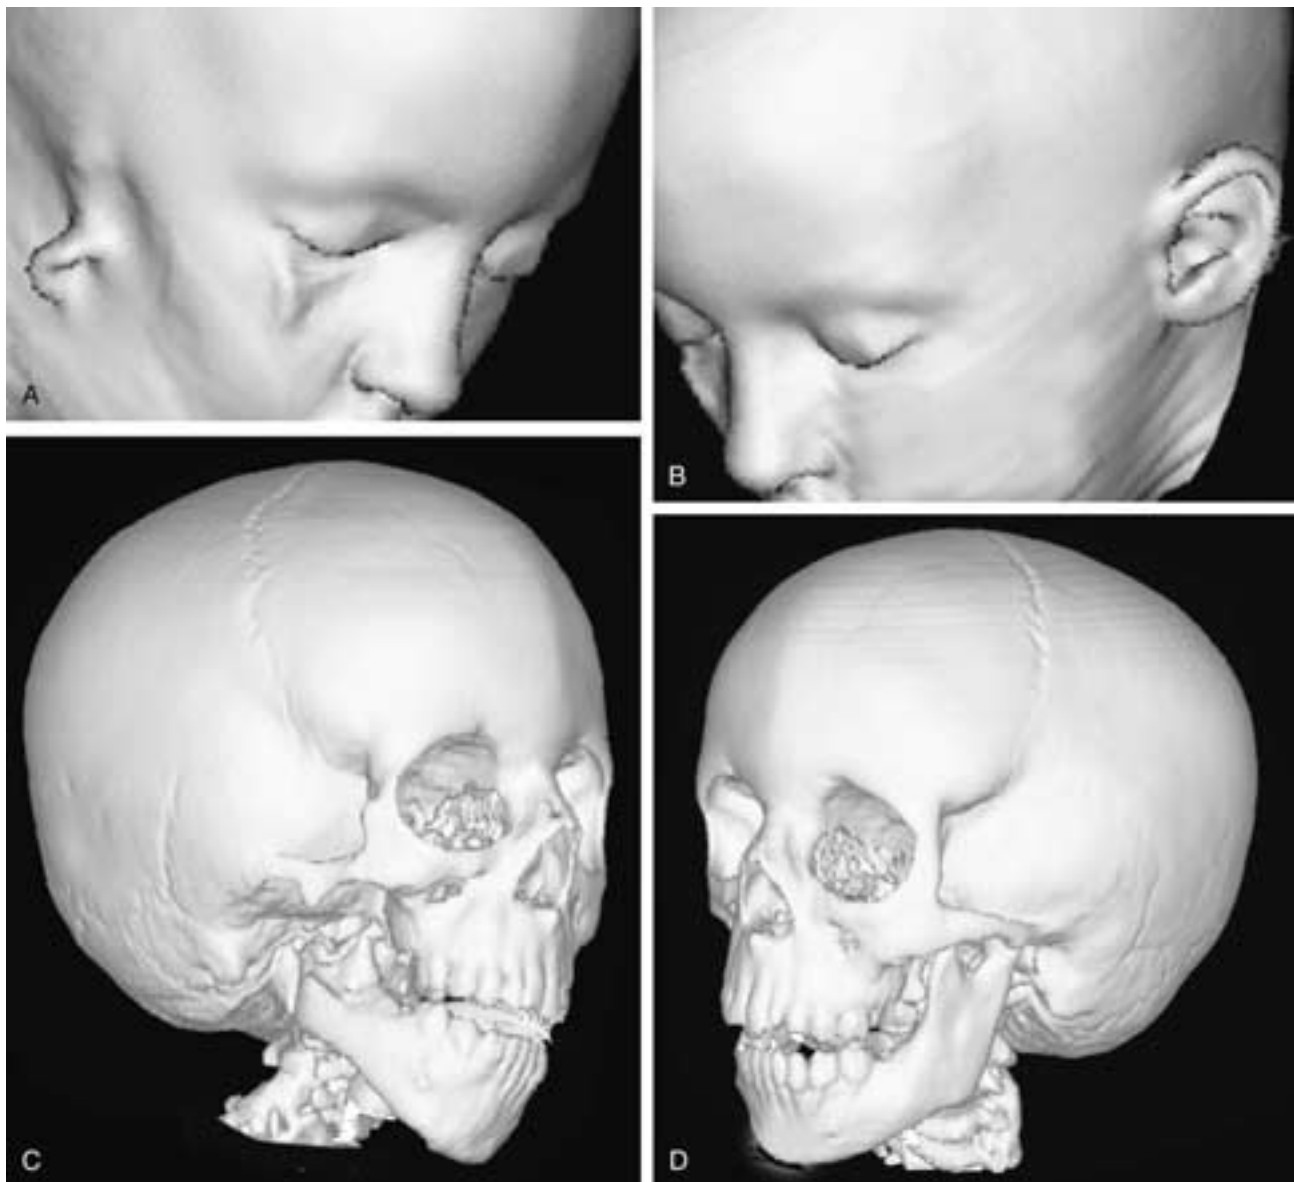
Goldenhar syndrome with vertebral malsegmentation. A to D, Three-dimensional CT surface renderings of the skin (A and B) and bone (C and D) of the two sides show right hemifacial microsomia with right microtia and hypoplasia of the right zygomatic arch, right maxilla, and right mandible, especially the angle and condylar process of the mandible. The lower right eyelid shows depression of the skin surface that corresponded to a coloboma.
